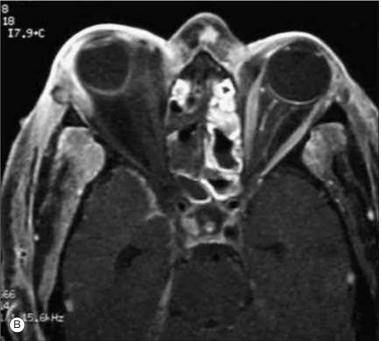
(A) Patient with mucormycosis of the right orbit, resulting in an orbital apex syndrome. (B) Axial view from orbital magnetic resonance imaging demonstrating mucormycosis of the ethmoid sinuses with extension into orbit.
